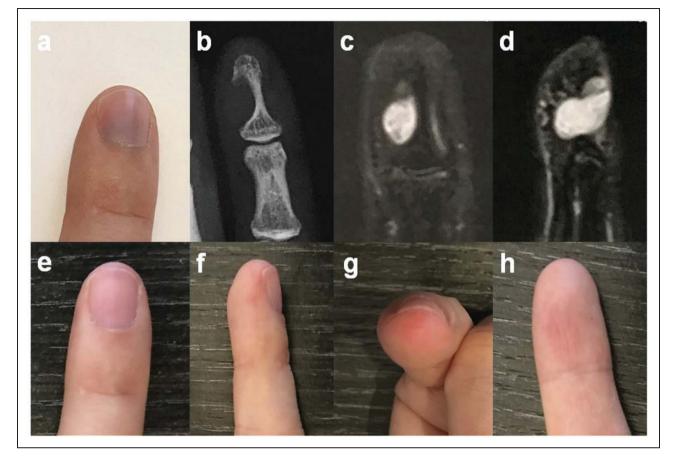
(a) Subungual bluish discoloration preoperatively and (b) radiograph showing radial side cortical thinning. (c) Coronal and (d) sagittal magnetic resonance images after gadolinium injection. Eight months postoperatively: (e) dorsal, (f) lateral, (g) fingertip and (h) pulp views.
